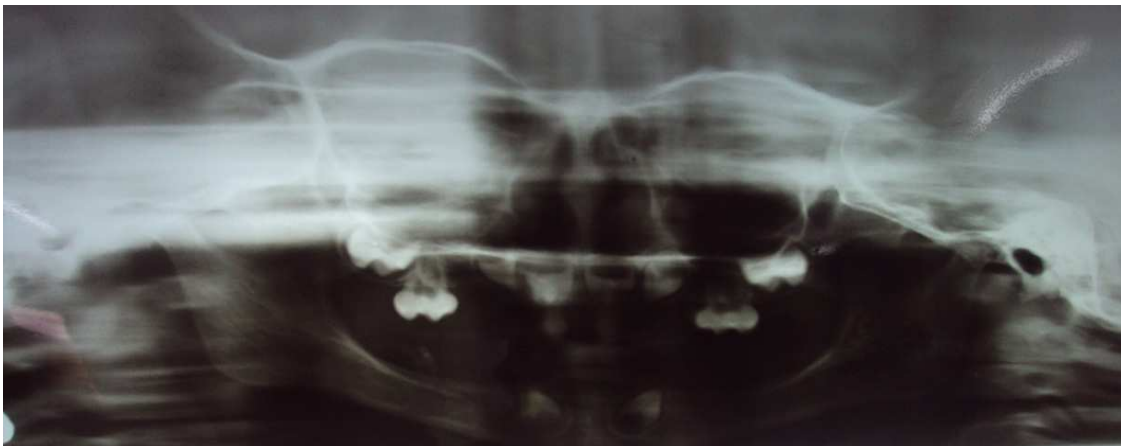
Orthopantomograph (OPG) revealed congenitally missing teeth
